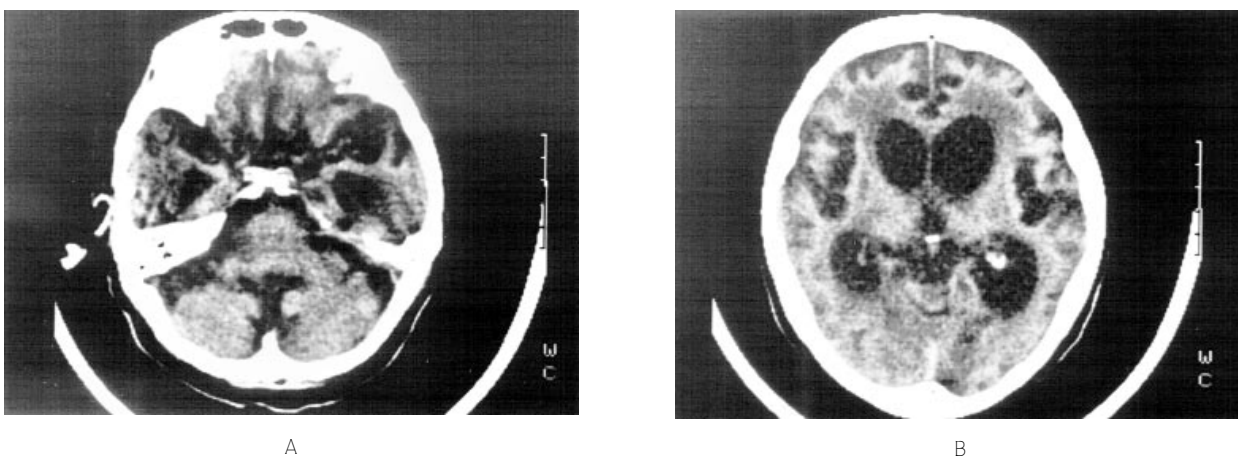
Axial CT scans (A-B) taken 6-8 months after prolonged anoxia show diffuse hypodensity in white matter with relative sparing of gray matter, relative hyperdensity in the thalami, brain stem and cerebellum, and cerebral and cerebellar cortical atrophy.
